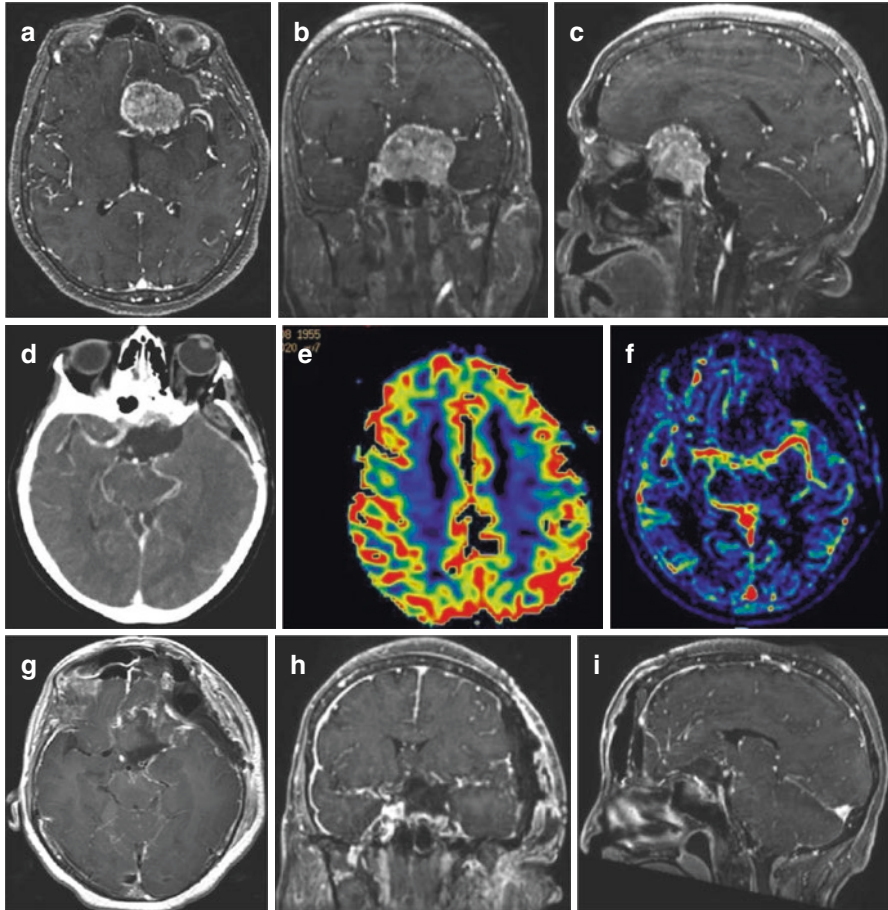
A large medial sphenoid wing meningioma on a 45-year-old woman presenting with headache. (a–c) Axial, coronal, and sagittal T1-weighted MRI scans with Gadolinium, respectively, showing tumor extension and encasement of the left ICA. Preoperative balloon test occlusion revealed tolerance to ICA ligation. Accordingly, a subtotal Simpson II resection was performed using a fronto-orbito-zygomatic approach. (d) Postoperative computed tomography (CT) scan with contrast showing no ACI on the left side. (e, f) Postoperative PWI/MRI scans showing sufficient brain perfusion (the anterior territory is shown nicely perfused in e, and the left MCA is shown in f). (g–i) Postoperative T1 MRI scans with gadolinium showing gross total resection
